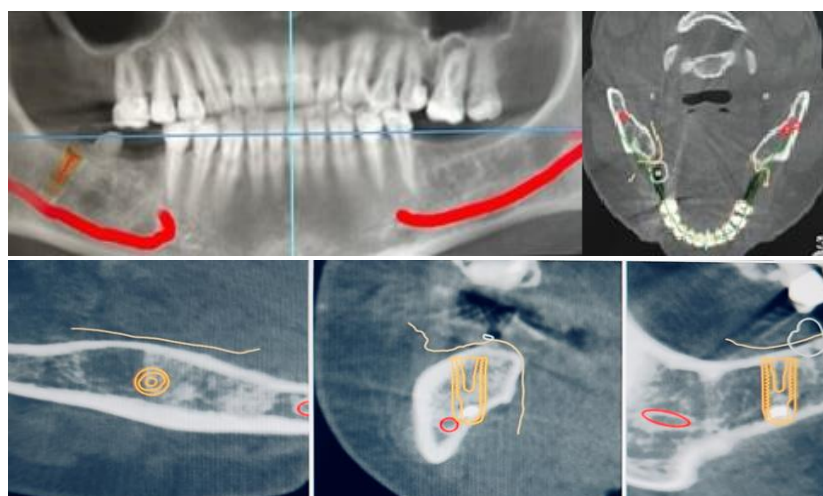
a, b, c, d. Computed tomography software for surgical implant planning, used for planning surgical drill template, for access to material
